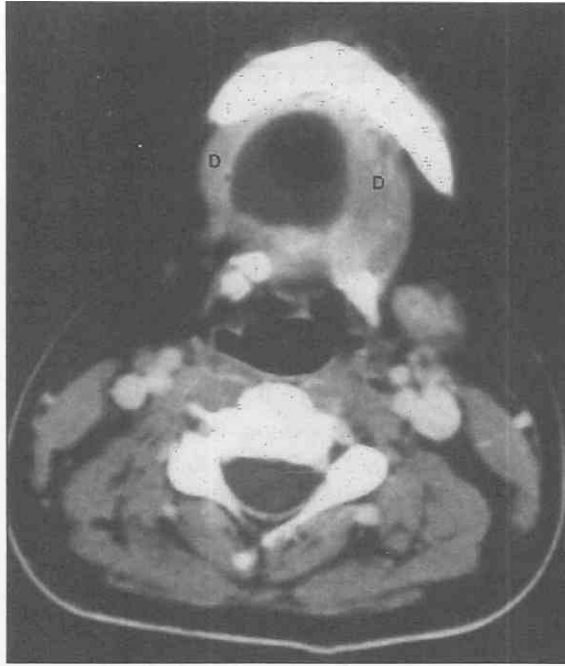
Dermoid cyst. Axial contrast-enhanced CT scan demonstrates a mass with peripheral rim enhancement in the submental triangle. The mass contains a fatty component anteriorly and a fluid component posteriorly. D, Anterior bellies of the digastric muscles. The central portion of the hyoid bone is absent because of previous surgery to remove a thyroglossal duct cyst. (From Reede DL, et al: *Nonnodal pathologic conditions of the neck*. In Som PM, Bergeron RT (eds): *Head and Neck Imaging*, 2nd ed. St. Louis, CV Mosby, 1991.)
